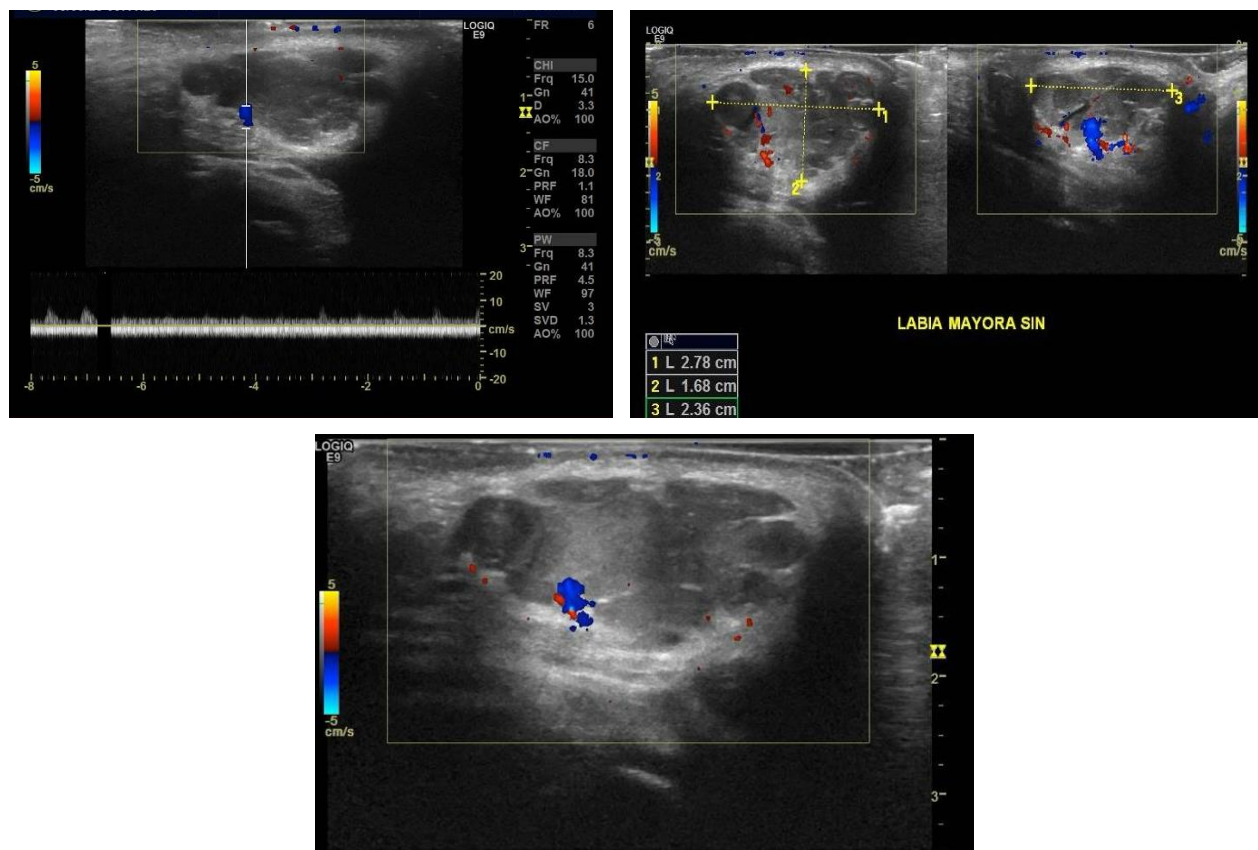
Doppler ultrasonography of the vulvar mass : well defined septated cystic lesion with internal echoes and septal flow measuring 2.3 x 2.7 x 1.6 cm in the left labia majora. A low flow lesion was noted.
